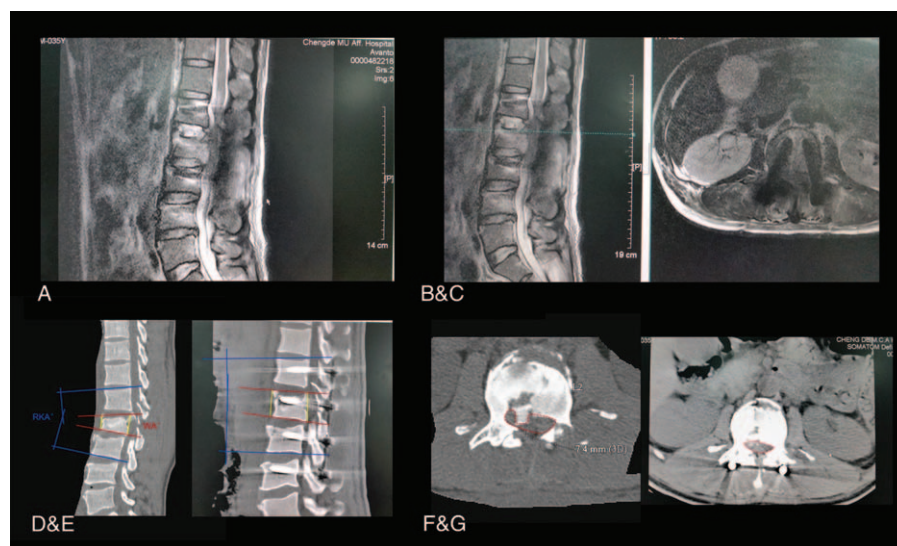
Postoperative magnetic resonance imaging (A–C) showing the bone fragments had been completely removed from the spinal canal. Computed tomography of preoperation (D, F) and postoperation (E, G). WA: angle between the superior and inferior endplate of the fractured vertebra; RKA: angle between the tangent of the superior endplate of the cephalad vertebra of the fracture and the tangent of the inferior endplate of the caudal vertebra (D, E). The spinal canal was indicated by dotted lines (F, G).
